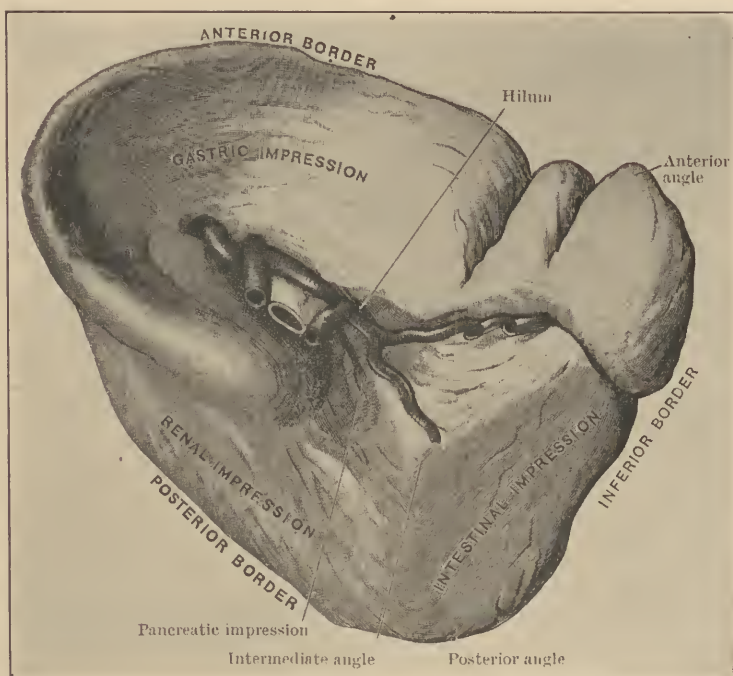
THE SPLEEN—VISCERAL ASPECT. (Courtesy Cunningham, Anatomy.)
